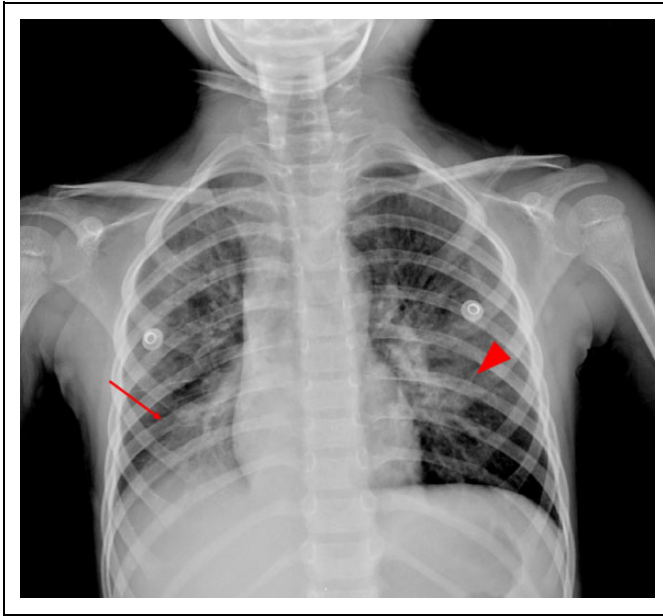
Chest radiograph showing pneumonic consolidation in the right lower lung field (arrow) and haziness around the wall of the left bronchus (arrowhead).
